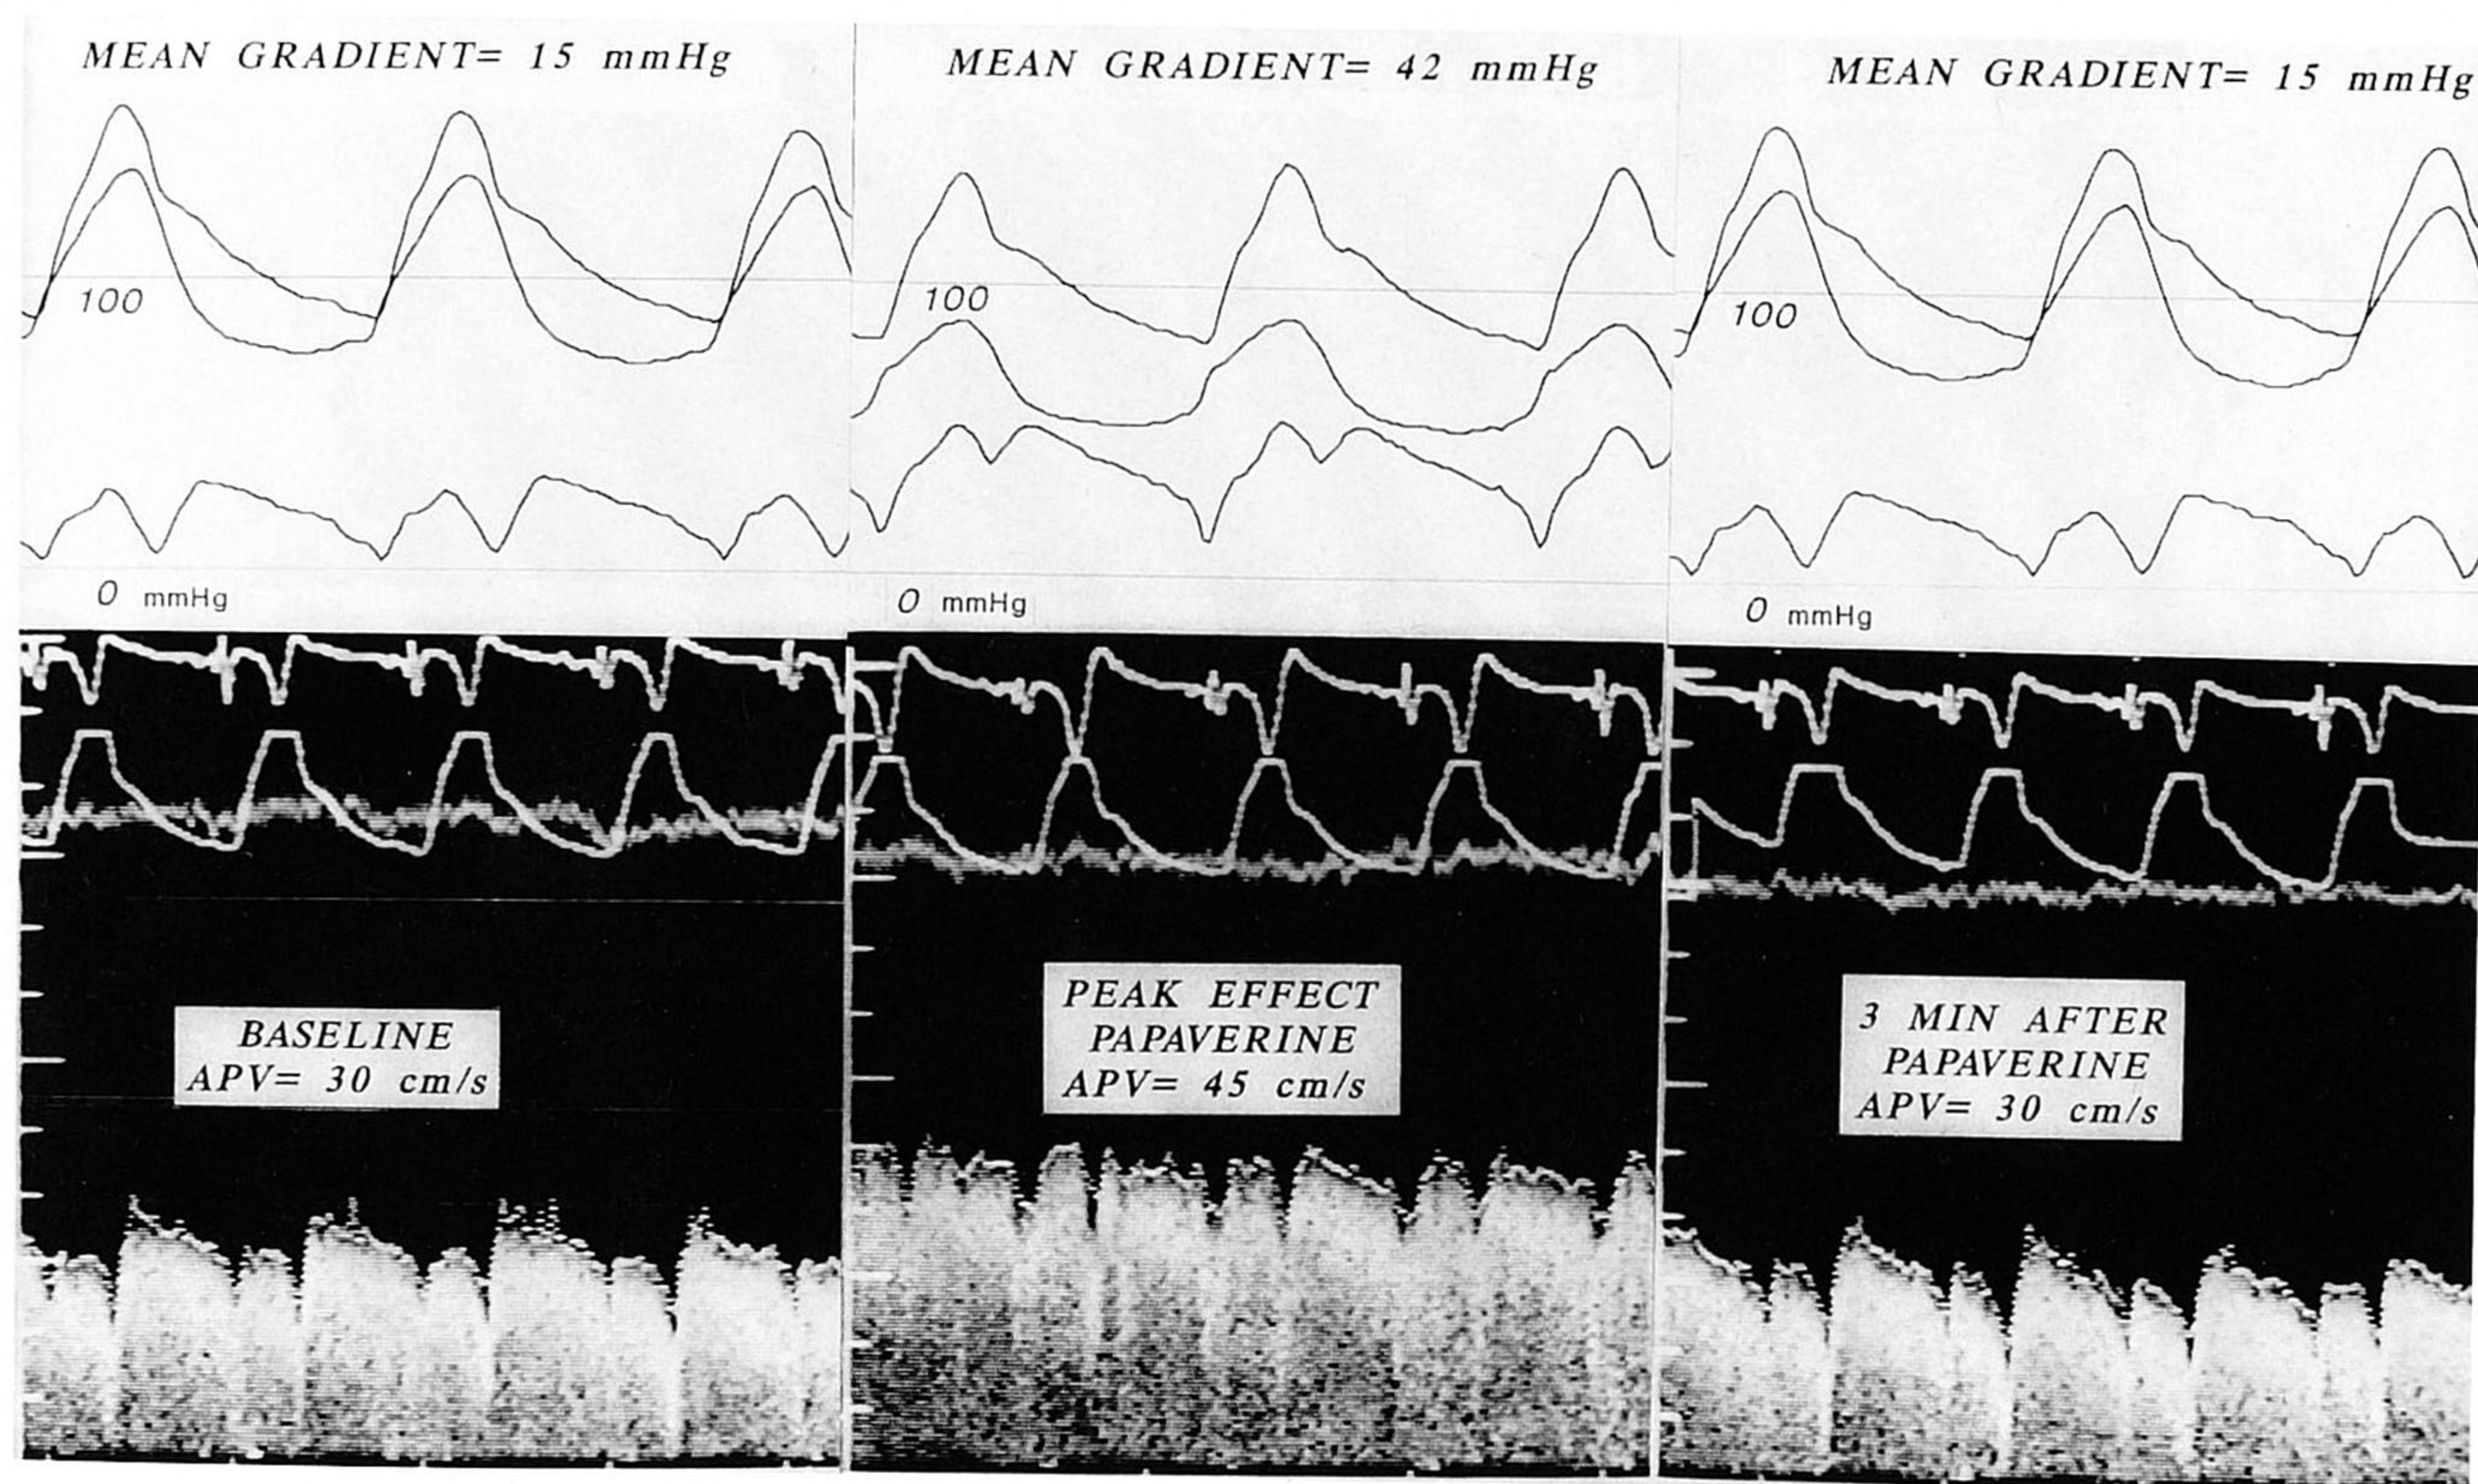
Simultaneous recording of proximal and distal coronary pressures and derived transstenotic pressure gradient (lower line) immediately before injection of papaverine (baseline, on the left), at peak hyperemia (middle), and 3 min after restoration of baseline conditions (on the right). The corresponding Doppler tracings are shown in the lower images. Note the automatic detection of the maximal BFV (dotted line tracking the Doppler envelope obtained from the spectral analysis of the signal). The indicated time averaged maximal BFV (APV, cm/s) is automatically calculated in the last 2 displayed beats.
